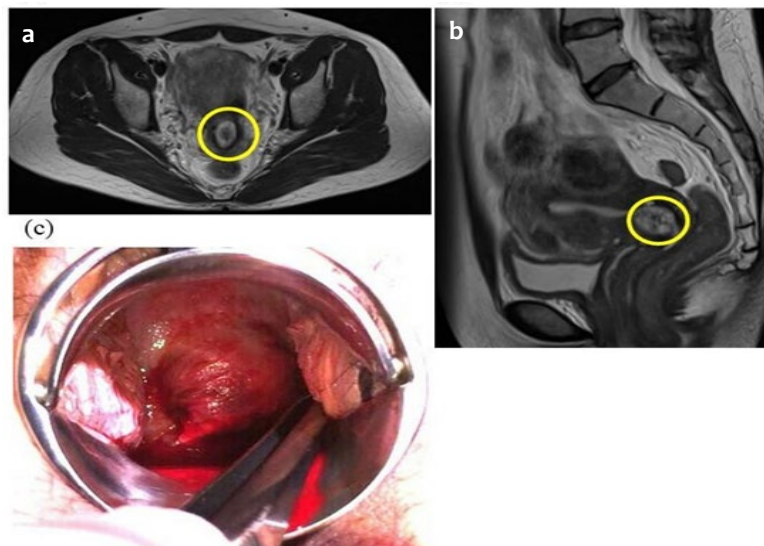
A medical examination by magnetic resonance imaging (MRI) scans at a hospital revealed the presence of a uterine myoma (Figure 1a and b). There was a massive active bleeding from the external cervix (Figure 1c).
